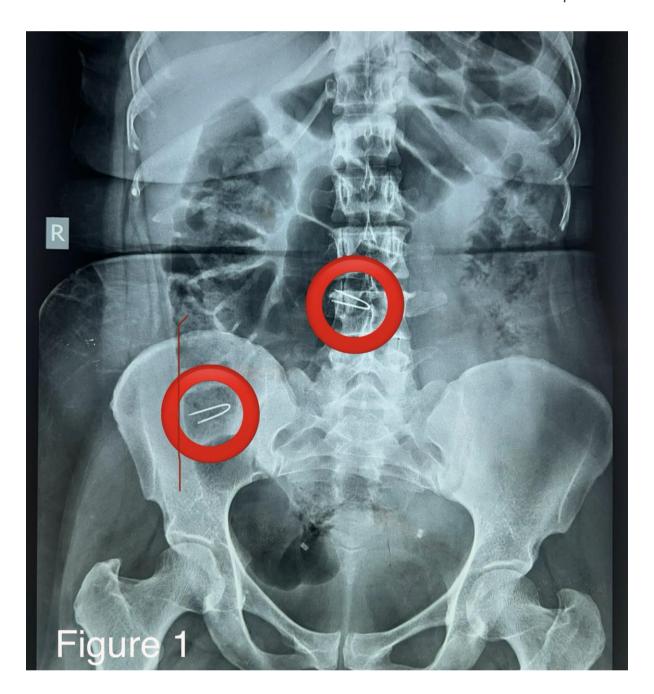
erect abdomen xray showing two metallic pins
